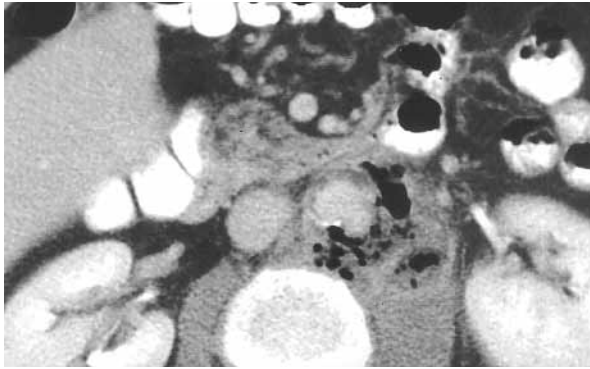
Enhanced computed tomographic scan reveals a large paravisceral aortic aneurysm with gas bubbles and periaortic fat stranding suggestive of infected aortic aneurysm.
